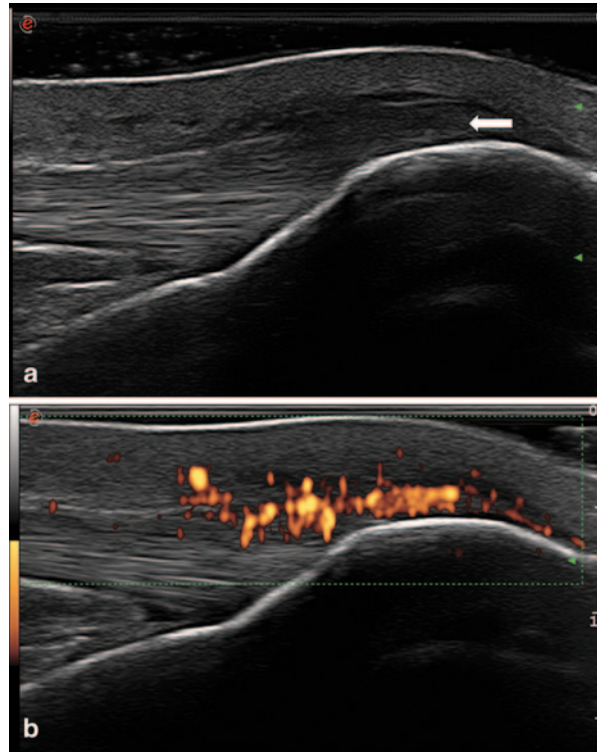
Enthesopathy of the distal patellar tendon in long axis. (a) Gray scale shows increased thickness and hypoechoic changes (*arrow*). (b) Power Doppler signal in the same hypoechoic area
